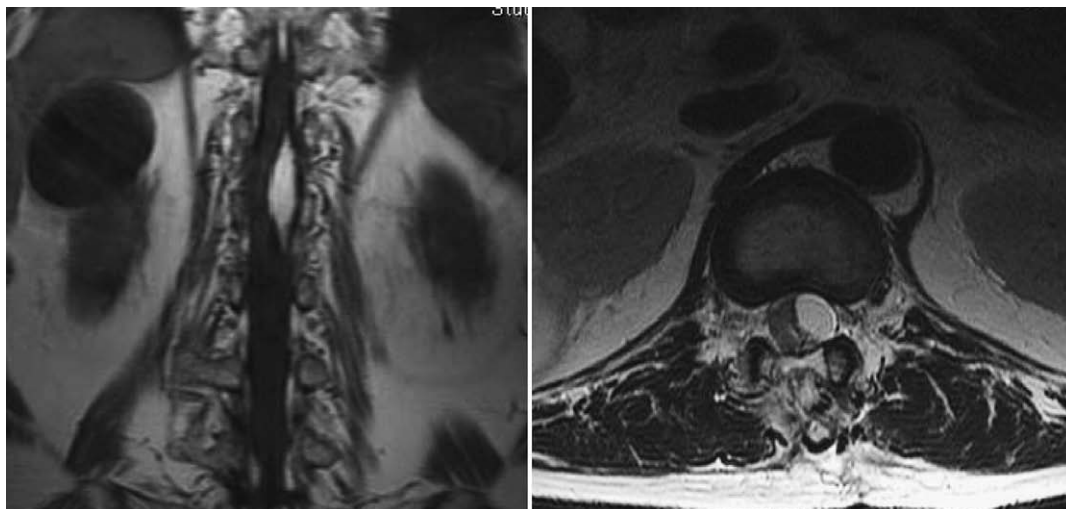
Postoperative MRI. Coronal T1-weighted and axial T2-weighted images.
